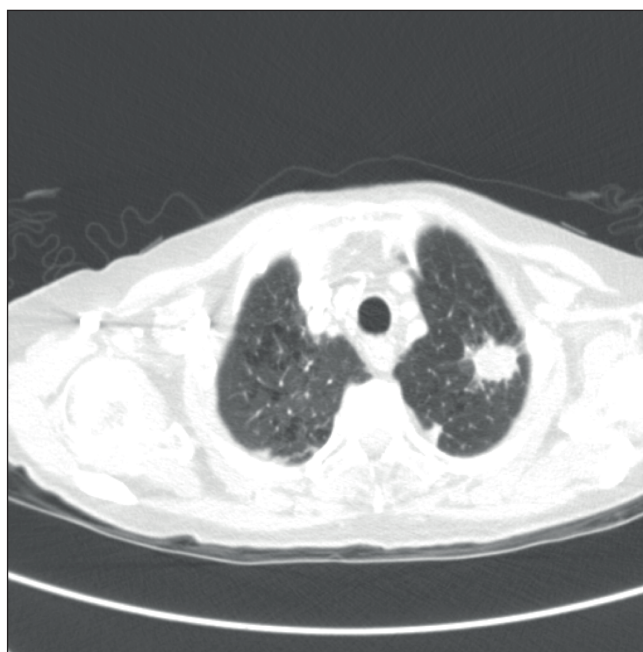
left Apical Tumour, CT image
